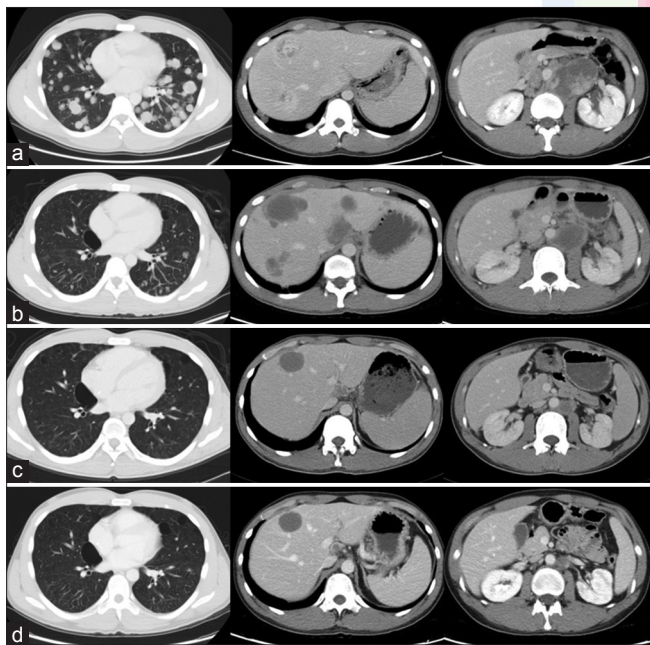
Computed tomography scans showed (a) multiple pulmonary nodules, hepatic nodules, and para-aortic masses in February, 2017. (b) Larger hepatic nodules, lesser pulmonary nodules, and smaller para-aortic masses after four cycles of EP. (c) Pulmonary nodules subsided, and cystic hepatic lesions remained after four cycles of TI- high-dose 5-fluorouracil and leucovorin. (d) Stationary cystic hepatic nodules and para-aortic masses after four cycles of maintenance high-dose 5-fluorouracil and leucovorin
